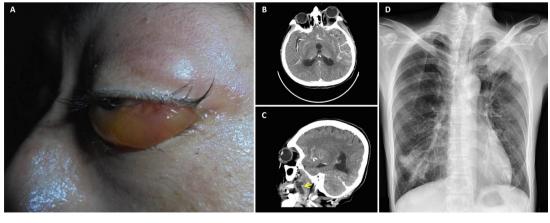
A 47-year-old man developed a variant of Lemierre's syndrome. (A) Left eye proptosis. (B) CT imaging of the brain revealed left superior and inferior ophthalmic vein engorgement, suspected cavernous sinus thrombosis related, (C) an abscess over left pterygoid muscles. (D) Chest X-ray revealed mass-like lesions over left-upper and right-lower lung fields.
